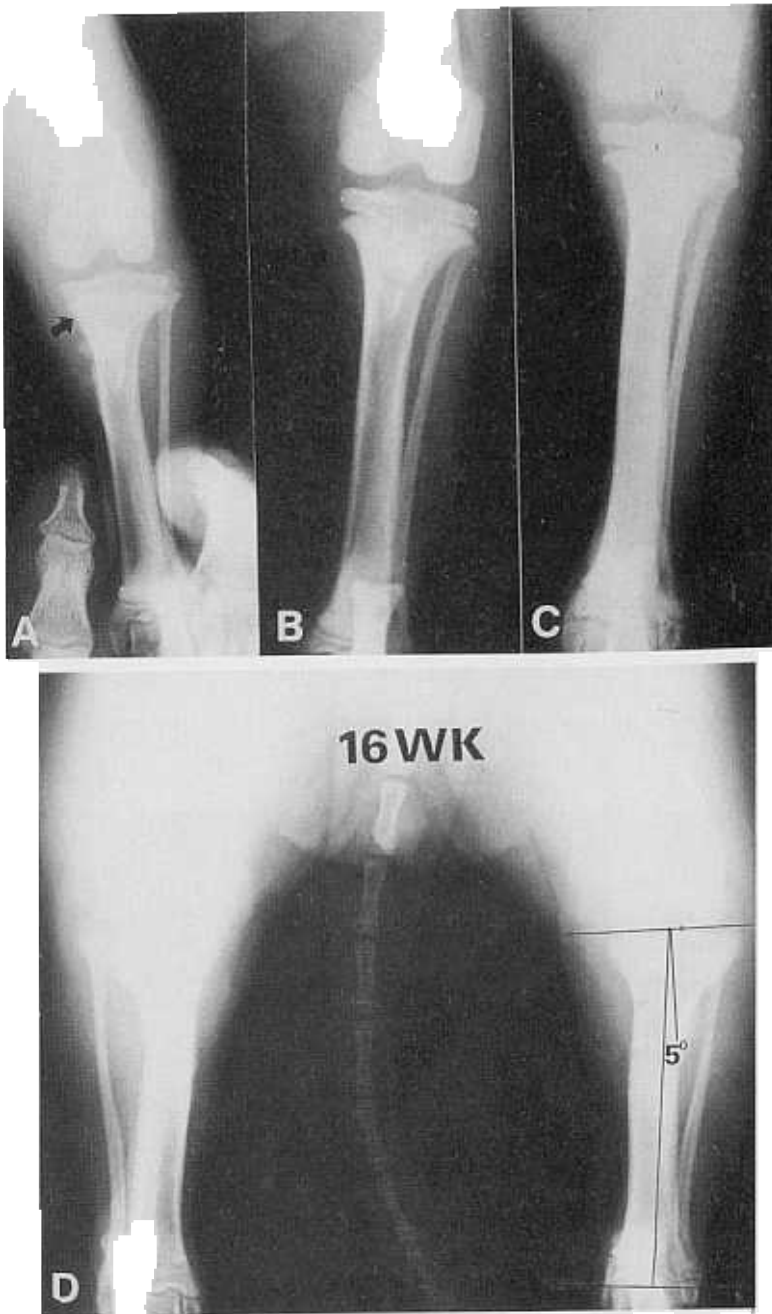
Serial radiographic changes after chondrocyte transplantation on the medial aspect of proximal tibial epiphyseal defect area.
